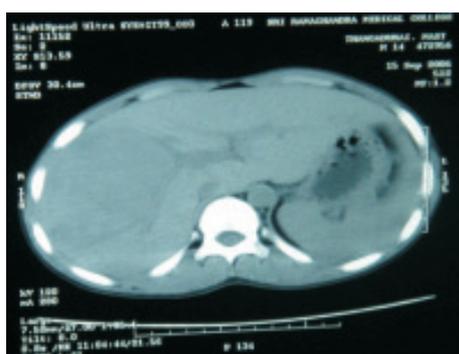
Plain CT scan showing a hypodense lesion in the right lobe of liver
